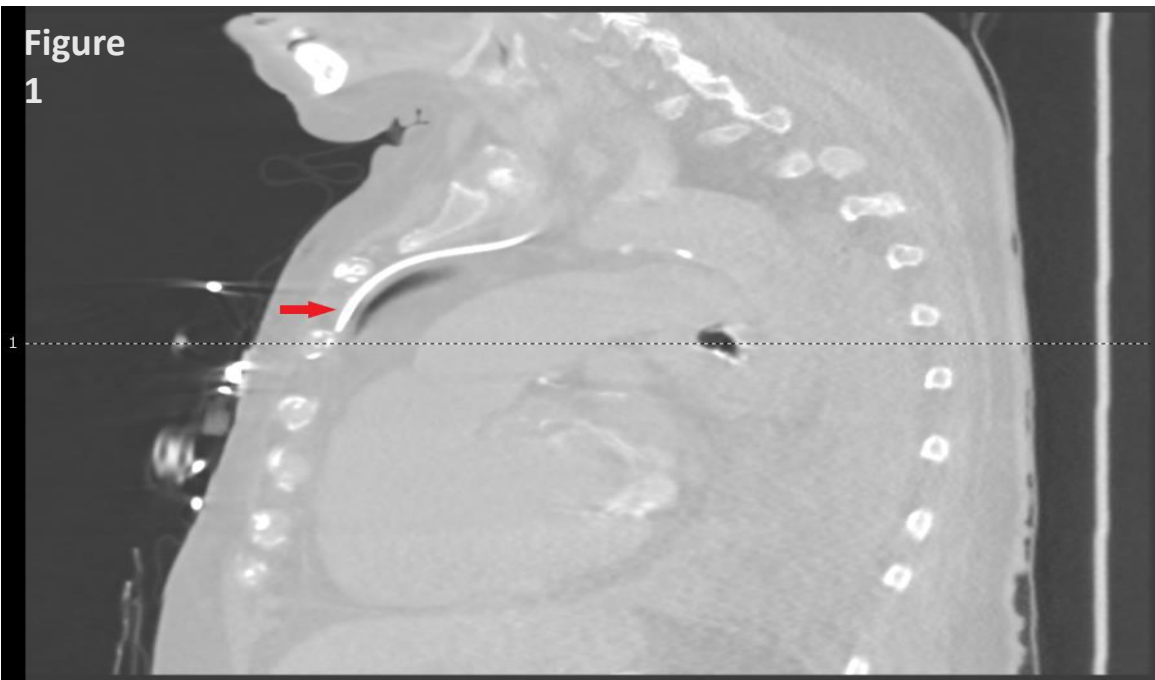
Computed tomography sagittal view of left-sided internal jugular vein central venous catheter (red arrow) coursing along the anterior mediastinum, consistent with placement in the left internal thoracic vein
